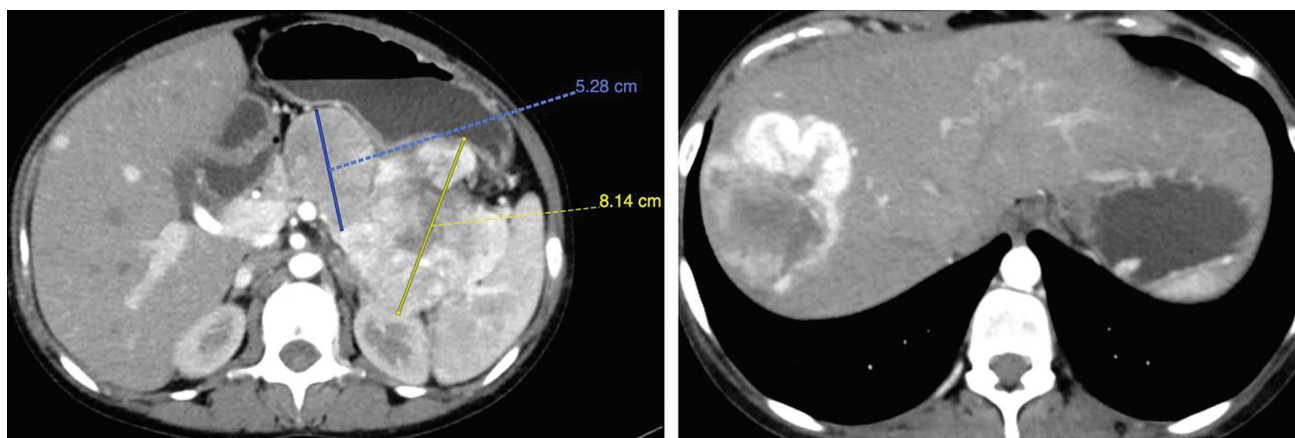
Triphasic CT shows lobulated, heterogenous, hyperenhancing partly exophytic focal lesion with central hypodense area with necrosis without calcification involving distal body and tail of pancreas. An irregular hyperenhancing focal lesion with central necrosis noted in segment 7/8 of liver. Few tiny well defined hyperattenuating lesions also noted in segments 6 and 4.
